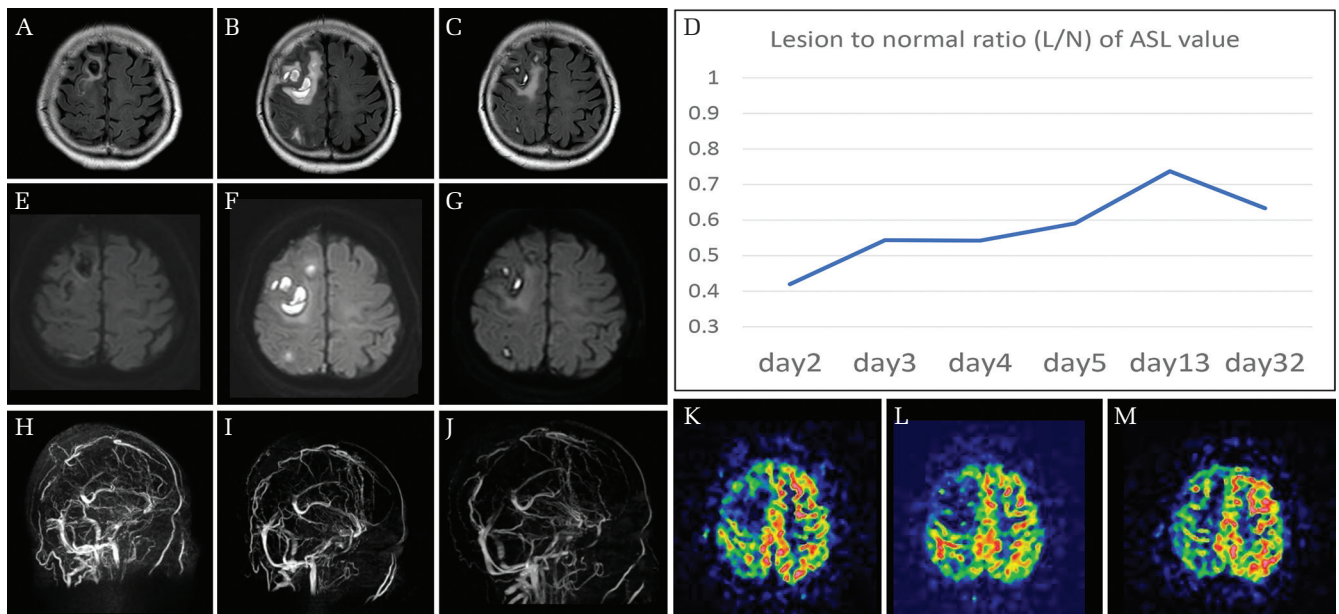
The sequential change of the FLAIR (A, B, C), DWI (E, F, G), MRV (H, I, J), and ASL (K, L, M) for patient with superior sagittal sinus (SSS) thrombosis. Faint signal of the SSS with decreased ASL at the right frontal cortex can be found at Day 3 (H, K). While the patient showed expansion of the hemorrhage during this period (B, F), improvement of the ASL with only a partial recanalization of the sinus can be seen at Day 13 (I, L). Further improvement of the ASL and other parameters can be seen at Day 32 (C, G, J, M). The graph shows the serial change of the ASL signal by lesion to normal ratio (L/N) (D).
